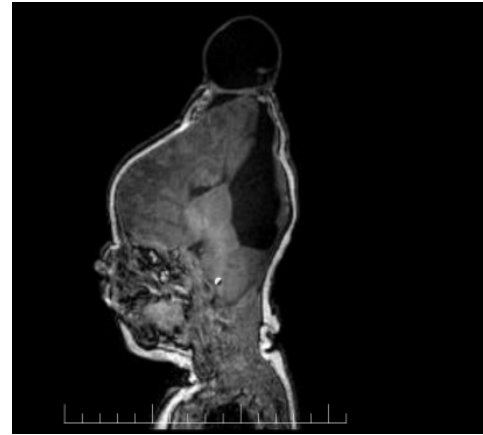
Sagittal view of MRI showing cranial meningoencephalocele in the high parietal region.
